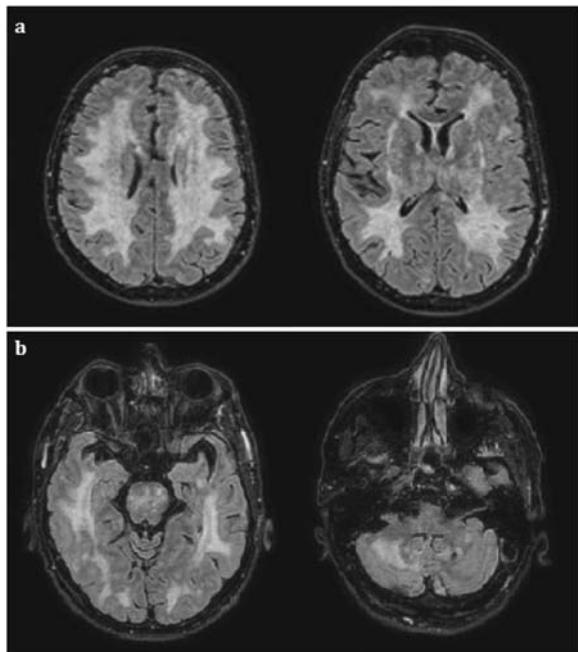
(a-b) MRI FLAIR sequence showing widespread supra and infratentorial white matter damage.
